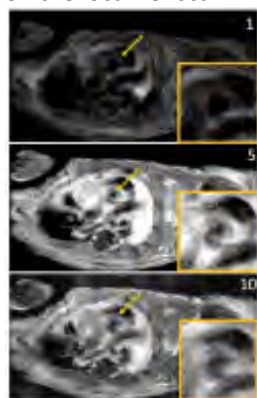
Represents the results. Compressed sensing reconstruction of self-gated DCE-MRI of the aortic root. Orange arrow and zoomed-in inserts, aortic root. Numbers indicate temporal frames. The same cardiac phase was depicted
